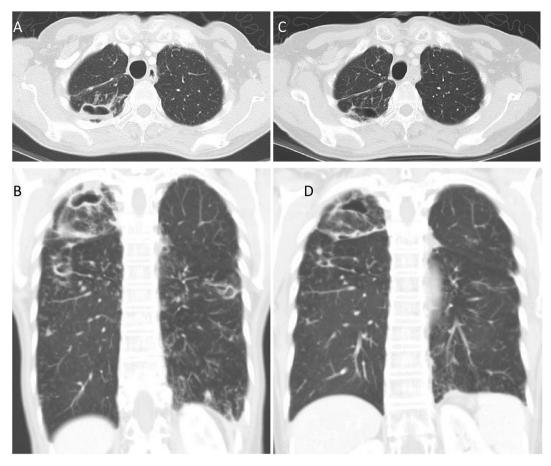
Fibrocavitary lung lesions in a 70-year-old woman with intermittent hemoptysis and progressive body weight loss over 6 months. Her sputum samples were AFB smear positive and culture positive for MAC. (A) Chest CT shows cavitation with subpleural thickening and patches of fibrotic change in the right upper lung. (B) In addition, CT scan discloses volume reduction of the right upper lobe and bronchiectasis in left lower lobe. (C, D) After daily anti-MAC therapy with oral azithromycin, ethambutol, and rifampin for 12 months and parenteral amikacin in the initial 2 months, chest CT reveals improvement of the cavitary lesion and nodular inflammation over bilateral lung fields.
